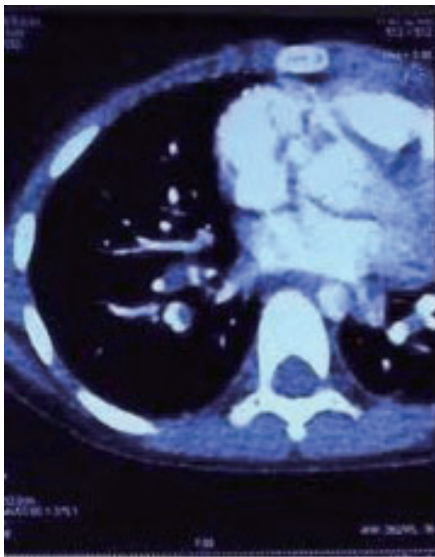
CT showed filling defect in right lower pulmonary artery after intravenous contrast injection.
